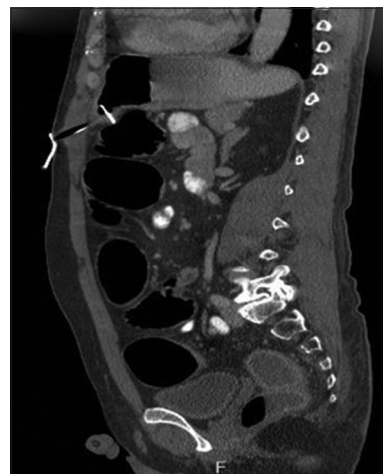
Computed tomography scan abdomen: Track of percutaneous endoscopic gastrostomy tube without colon entrapment
